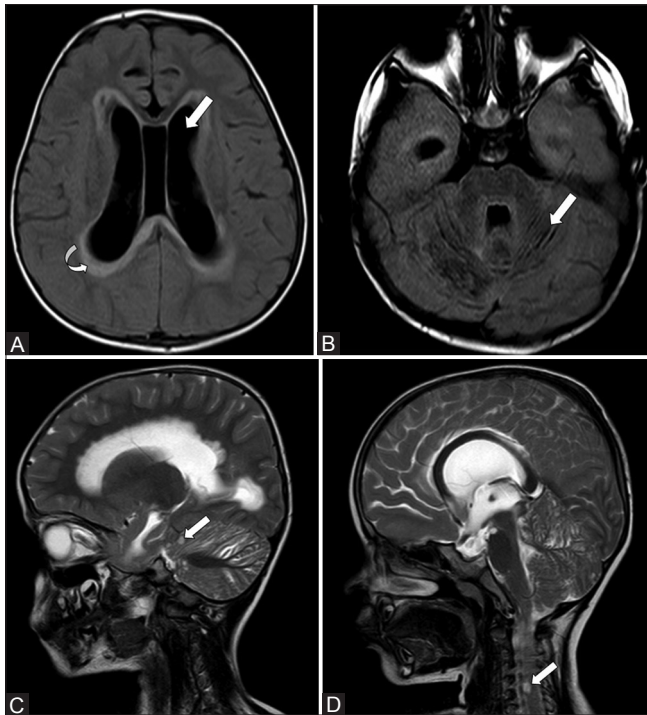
(A-D): (A) MRI findings (March 2013) a: T2 FLAIR axial image shows moderate hydrocephalus (straight arrow) with cavum septum pellucidum with periventricular hyperintensity (curved arrow) (B) MRI findings (March 2013): T2 FLAIR axial image shows prominent cerebellar foliae (straight arrow) (C) T2 sagittal image shows few hyperintense cystic lesions in the cerebellum (straight arrow). The cyst appears to be intraparenchymal without perilesional edema (D) T2 sagittal image shows few hyperintense cystic lesions in the upper cervical cord in extra medullary location (straight arrow)
